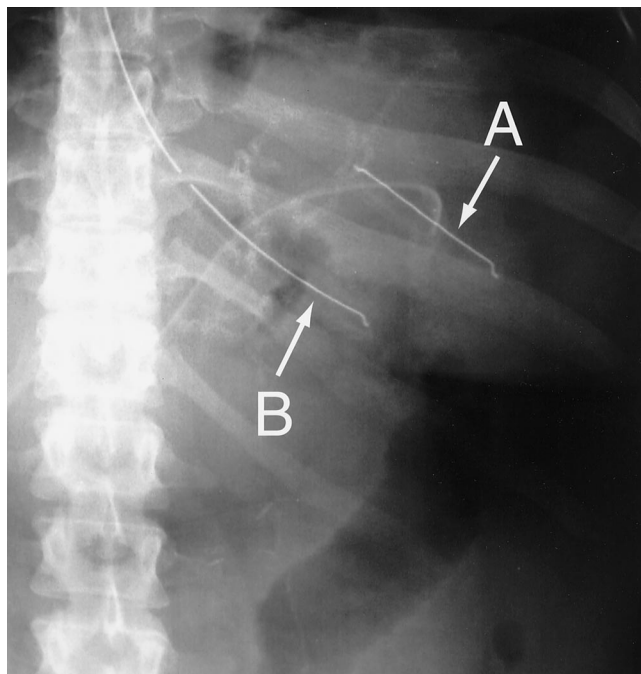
Radiograph of postoperative Day 1 Gastrografin swallow. A, Transected end of the nasogastric (NG) tube left in the gastric remnant. B, New properly placed NG tube replacing the transected one.
